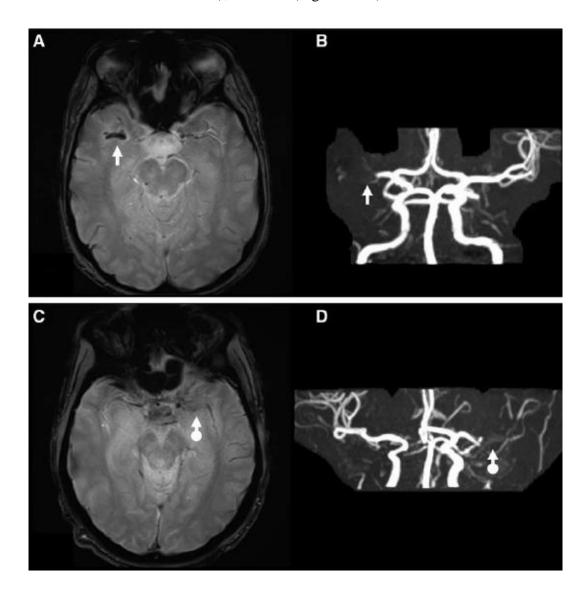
Examples of SVS + and SVS-. MRI of 2 patients presenting with (SVS)+ (A and B; white arrow) and SVS- (C and D; white arrow with dot). A and C, axial views of T2*- GRE imaging, (B and D) time of flight. Modified according to the reference (24).
